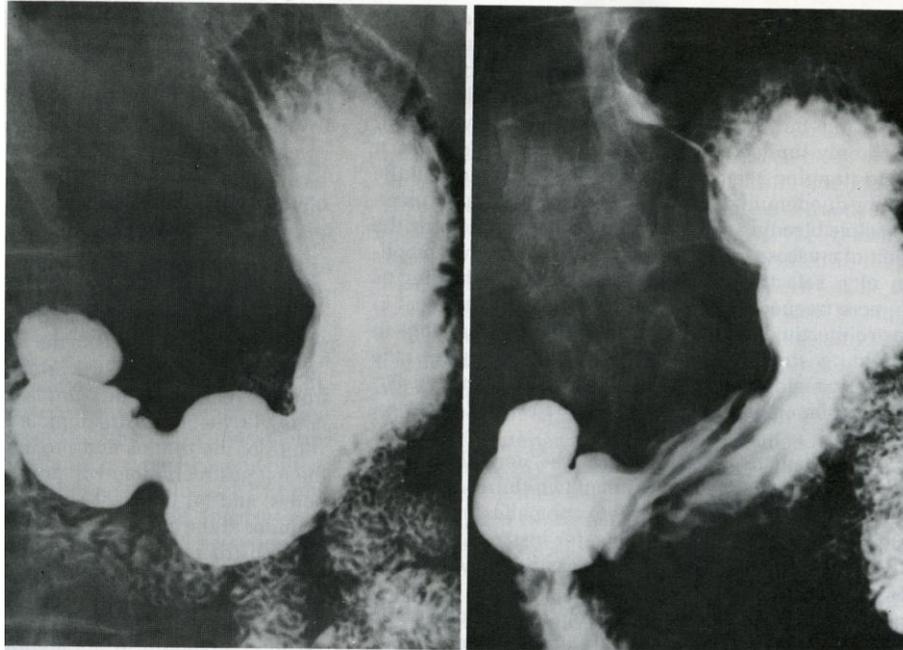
Radiographic appearance of the normal stomach.
